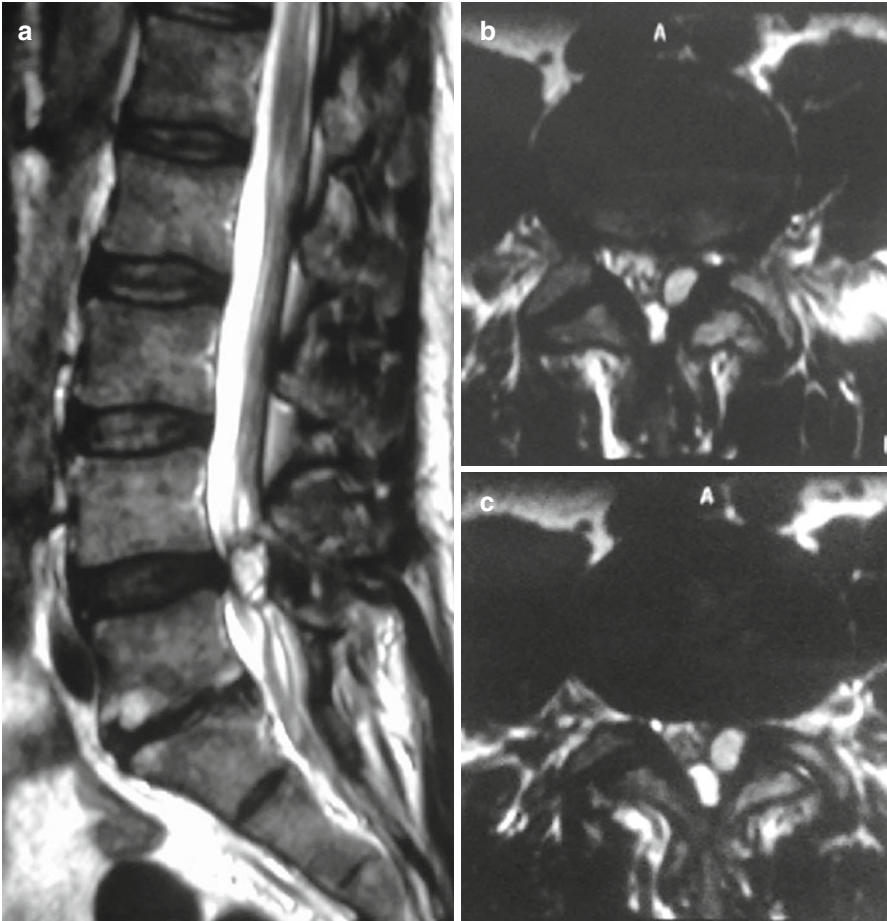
Preoperative MRI. Sagittal (a) and axial (b, c) T2-weighted images that show an L4–L5 true synovial cyst arises from the left L4–L5 facet joint
